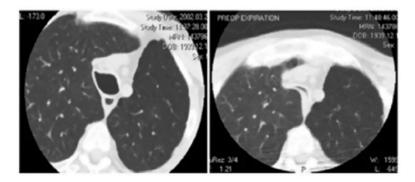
Dynamic CT. Left: During forced inhalation. Right: At exhalation. Reproduced with permission from Majid A, Sosa A, Ernst A et al. Pulmonary Function and Flow-Volume Loop Patterns in Patients with Tracheobronchomalacia. *Respir Care*. 2013;58(9): 1521–1526. (Figure 2, p. 1522). doi:10.4187/respcare.02277.
